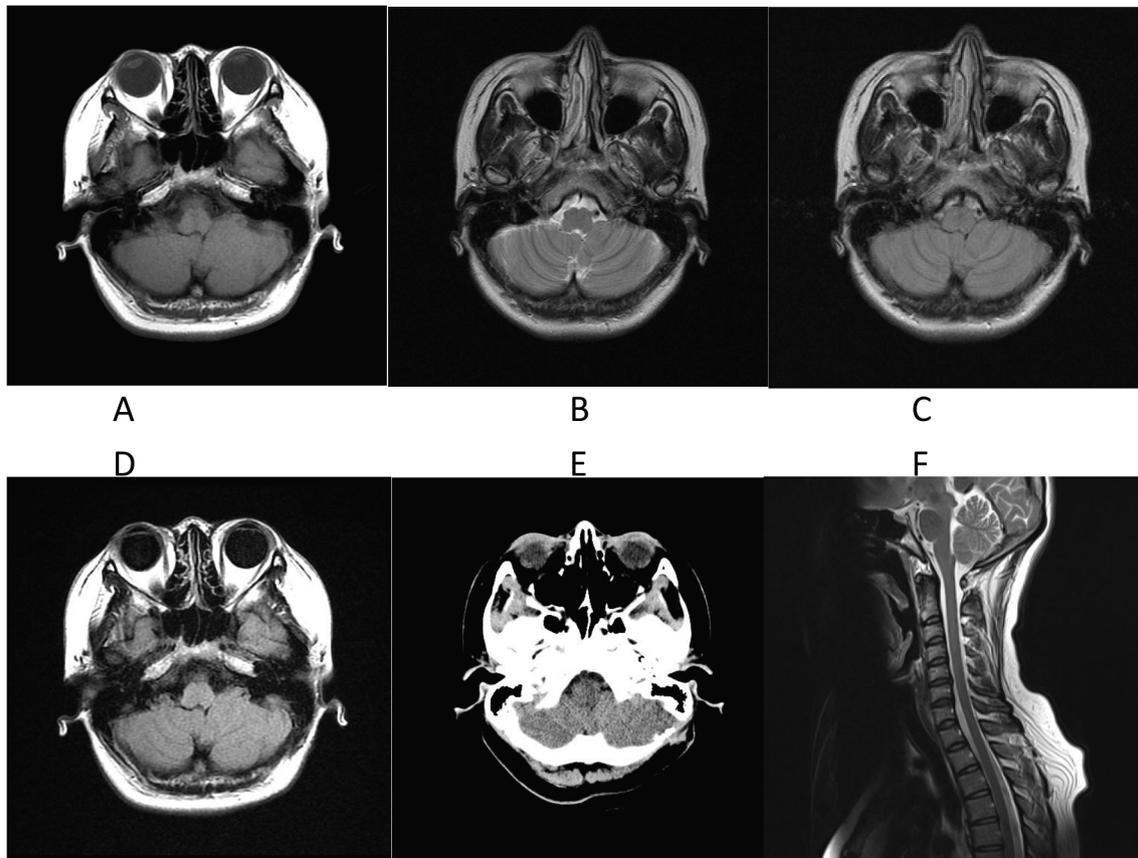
Brain MRI, T1 (A), T2 weighted image (B), FLAIR (C), T1 weighted image with gadolinium-diethylenetriaminepentacetate enhancement (D), brain CT (E), cervical MRI T2 weighted image of case 1.
